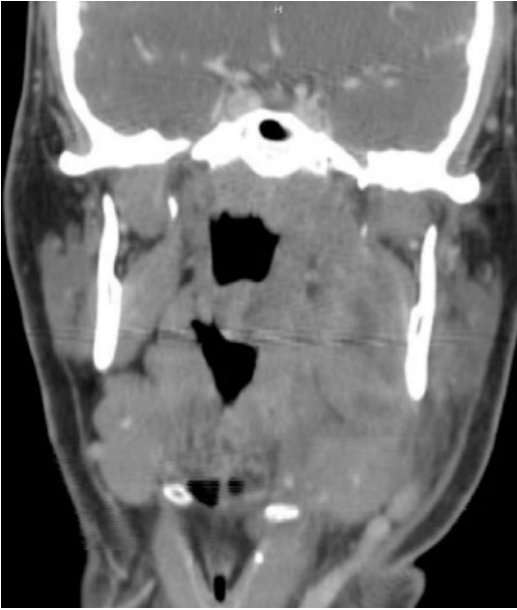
Coronal CT scan with contrast at the level of mandibular ramus. (Image courtesy of Dr. Damian Findlay)
